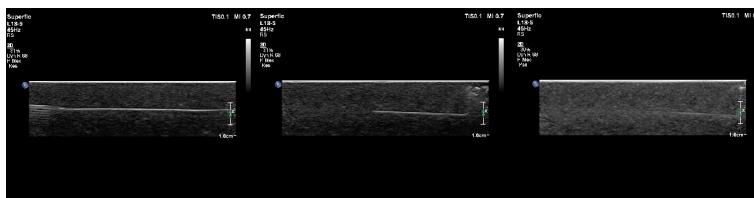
Ultrasound images indicating that capillary channels are seen via ultrasound. The image to the left was taken before injecting water 20 $\mu\text{l}/\text{min}$ though, the one in the middle was taken when the channel was half filled and in the last image the channel is filled. Artifact from the needle is seen image to the left
